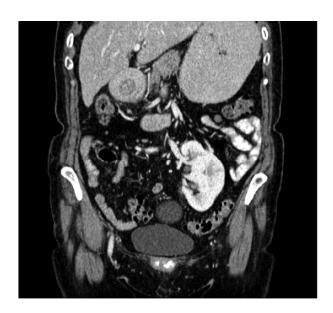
Coronal slice of a contrast enhanced CT abdomen/pelvis clearly demonstrating the "target sign" which is characteristic of GI intussusception. There is also an incidental finding of a left sided pelvic kidney. 197x109mm~(150~x~150~DPI)
